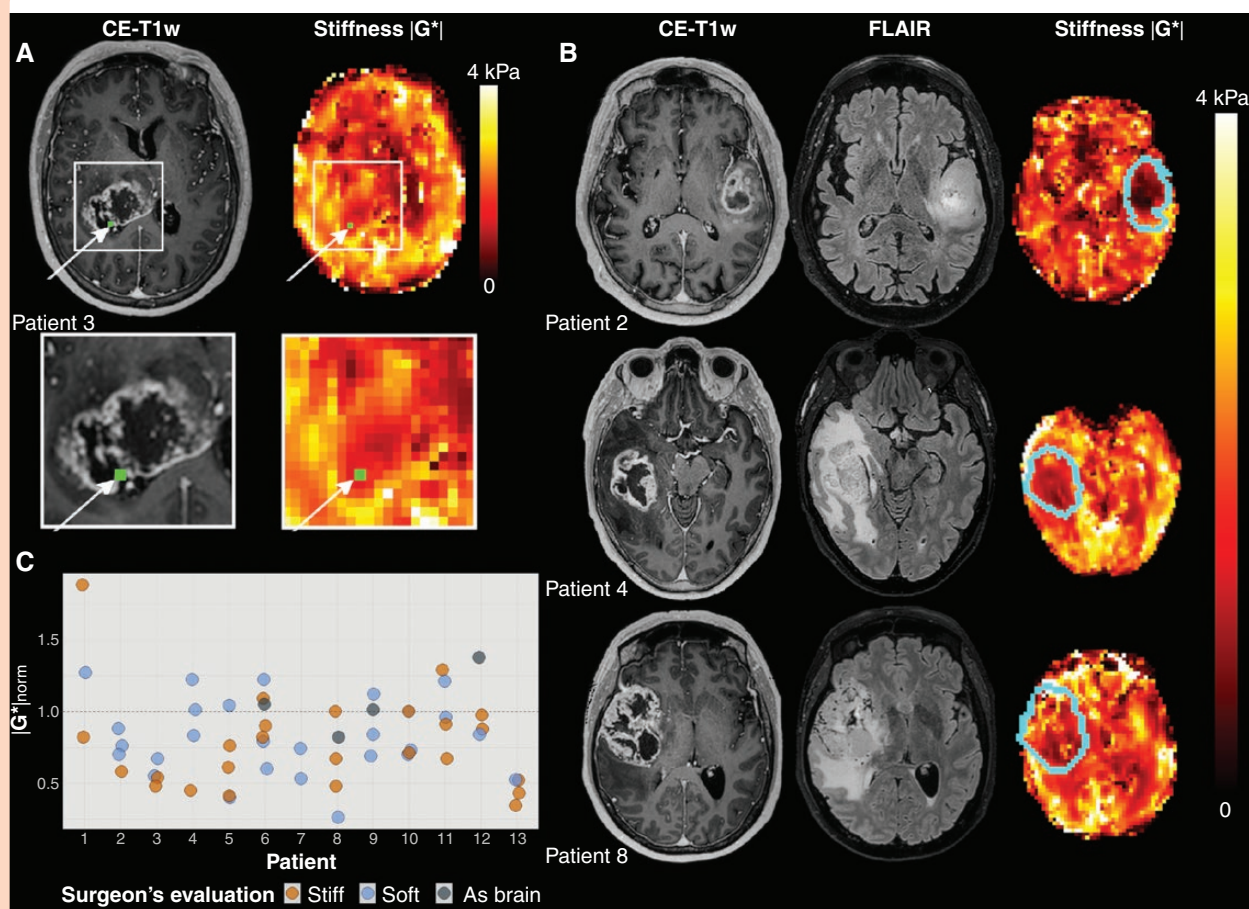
(A) Example of MRE imaging. The location of the tissue biopsy is shown in green in the contrast-enhanced T1-weighted image (CE-T1w) and the MRE stiffness map ($|G^*|$). (B) Representative images for three patients. From left to right: CE-T1w images, and $|G^*|$ map, with tumor outline overlaid. (C) Stiffness measurements for all biopsies per patient ($n = 56$). Normalized MRE-based stiffness $|G^*|_{\text{norm}}$ for all biopsies acquired for all patients ($n = 13$). The median normalized stiffness for biopsies evaluated by the surgeon as stiff was 0.71, with 0.79 for biopsies evaluated as soft. Biopsies found by the surgeon to be similar in consistency to healthy brain tissue had a median normalized stiffness of 1.03. The horizontal line at $|G^*|_{\text{norm}} = 1$ shows the mean stiffness in each patient's contralateral normal-appearing white matter.
